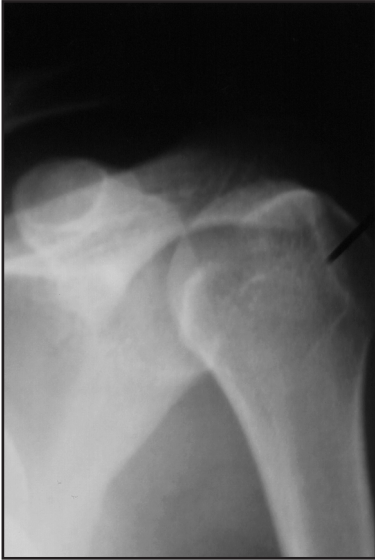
A Hill-Sachs lesion on an AP radiograph appears as a sharp, vertical, line of condensation, as indicated by the black line. The length correlates with the size of the defect. Hill-Sachs lesion on the AP view is best seen with the shoulder in internal rotation as shown here on this post-reduction radiograph where the patient's shoulder had been strapped to his chest.
